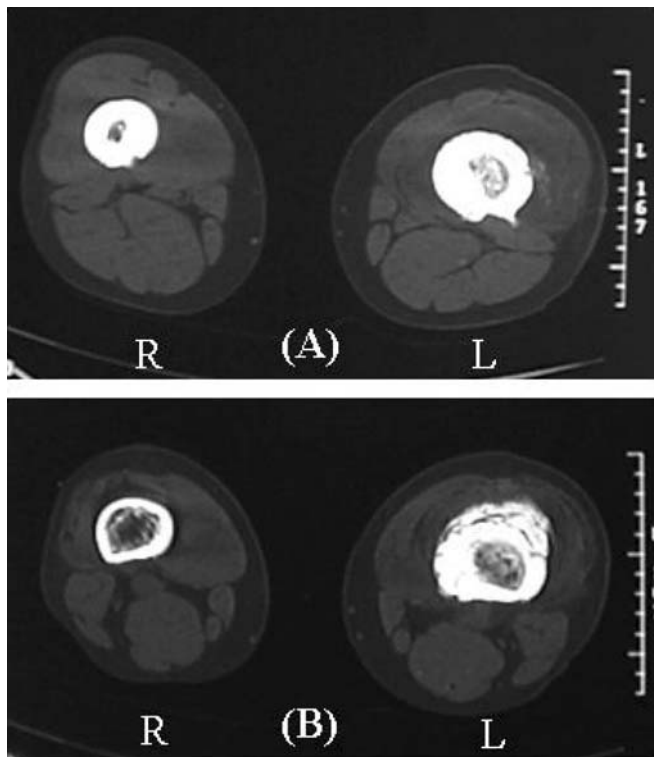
Axial computed tomography scan obtained at the age of 45 years. A Cortical thickening was detected in bilateral femora. B Laminar productive change was detected in the left femur on a distal slice
